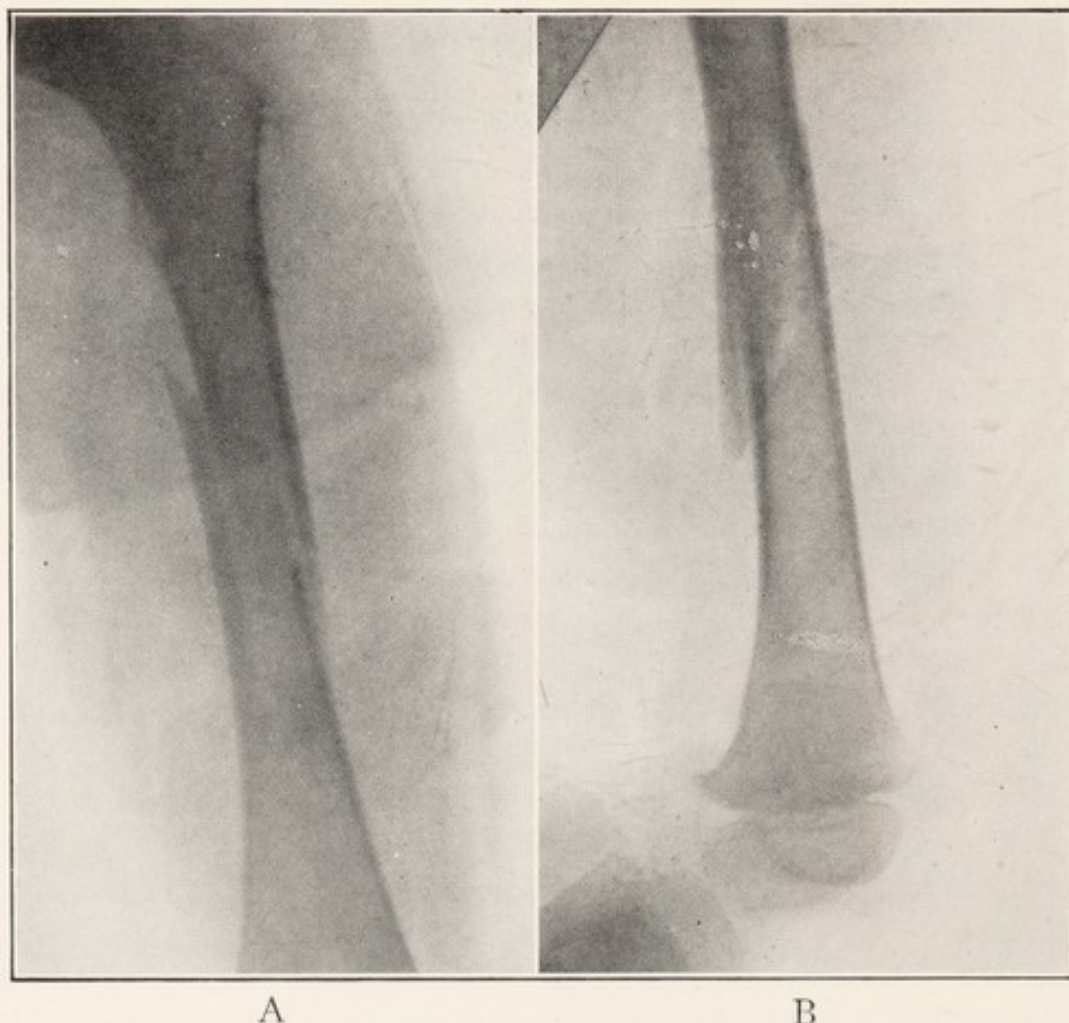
X-RAY SHOWING TRANSVERSE FRACTURE OF SHAFT OF FEMUR, ANTEROPOSTERIOR VIEW.
